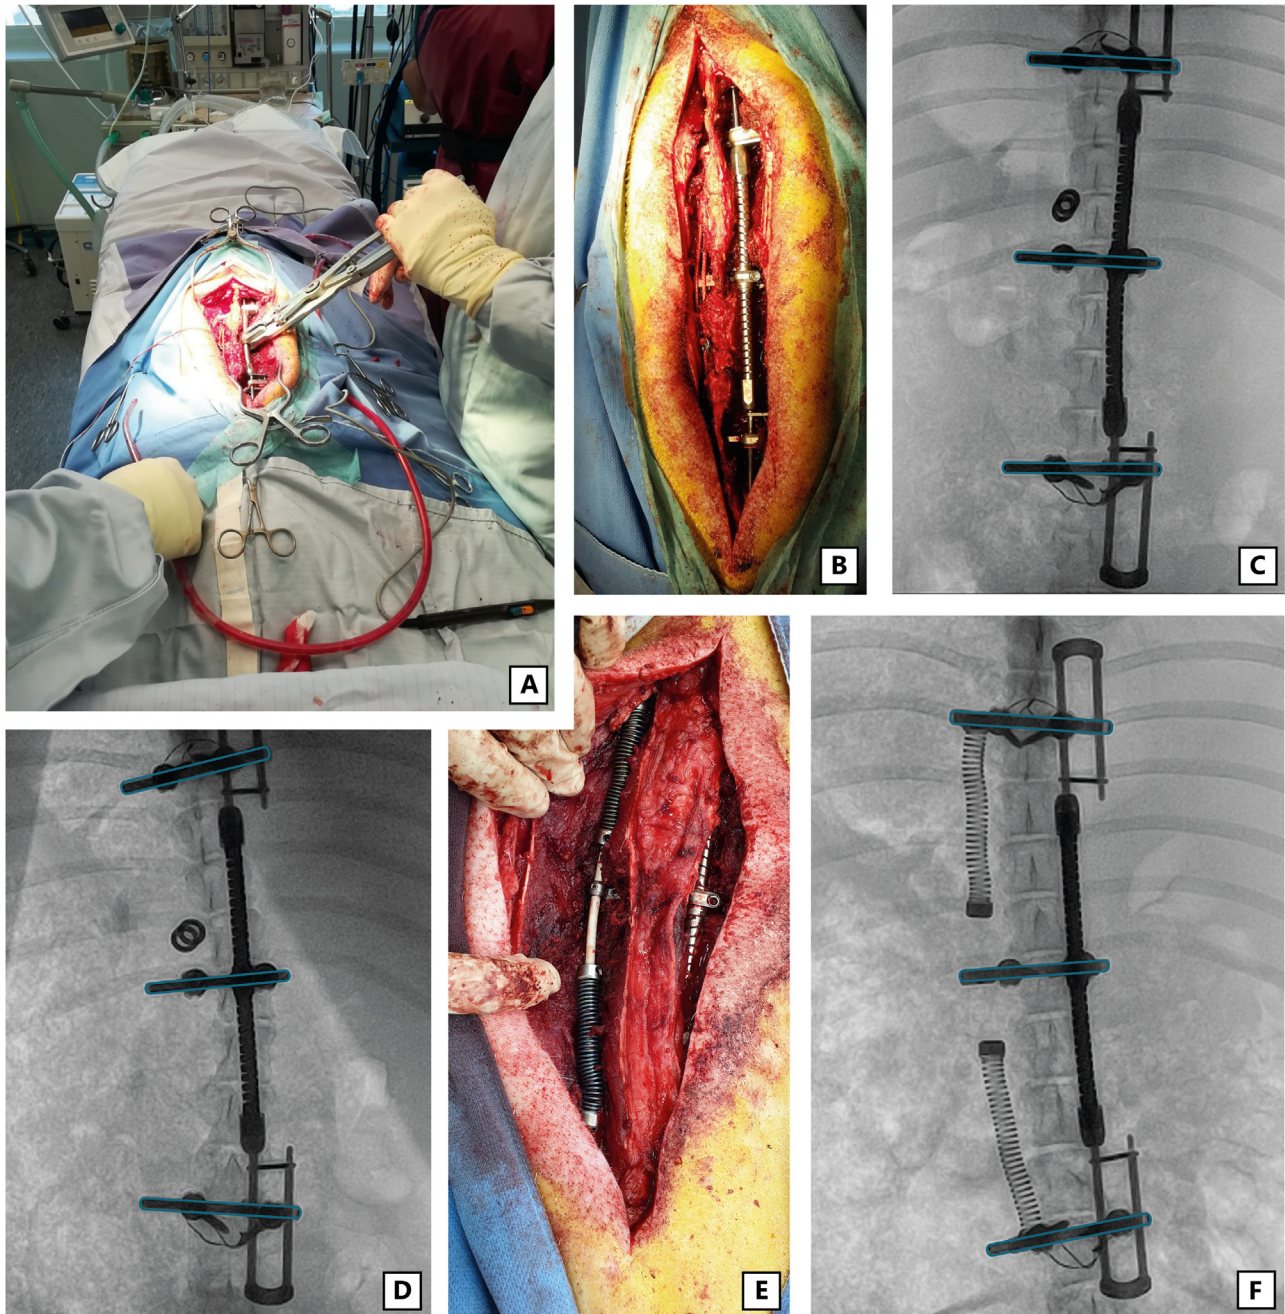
Induction- and reduction surgery. (A) During induction, the TSI is wound up by rotating it 45° in the clockwise direction (looking in the caudo-cranial direction), to deliver 2Nm torque. (B) Close-up of the TSI (right) and the implanted tether (left). (C) Radiograph immediately following induction surgery. The rails are outlined in blue to highlight the change in coronal deformity over time. The buckles with which the tethers are fixated can be seen on the left, the tether itself is radiolucent. (D) After 3 months, the scoliosis can be seen, including axial rotation. Also note the spinal growth seen as translation of the U-loops relative to the cranial and caudal anchors. (E) During the reduction surgery, the torsional spring force is reversed and two distraction springs on a (radiolucent) flexible PEEK rod are fixated to the left-side. (F) After 2 months, the scoliosis was reduced in the axial and sagittal plane, and was even overcorrected in the coronal plane.
